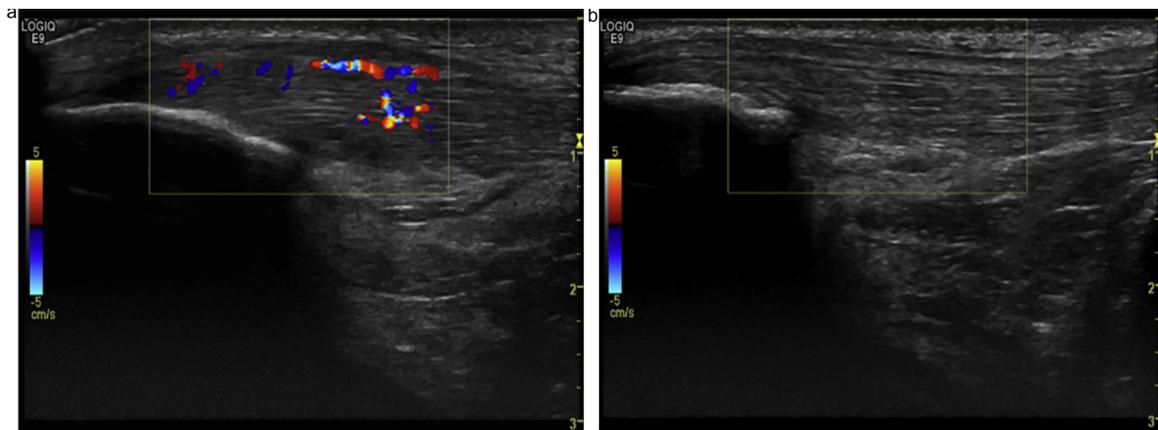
34-year old female basketball player with anterior knee pain. Longitudinal sonogram images of the patellar tendon (a) before and (b) 4 weeks after undergoing 3 courses of prolotherapy using 25% glucose injections in to the tendon. Initial image demonstrates tendon thickening and neovascularisation. Subsequent image demonstrates normal tendon morphology and obliteration of neovessels.
